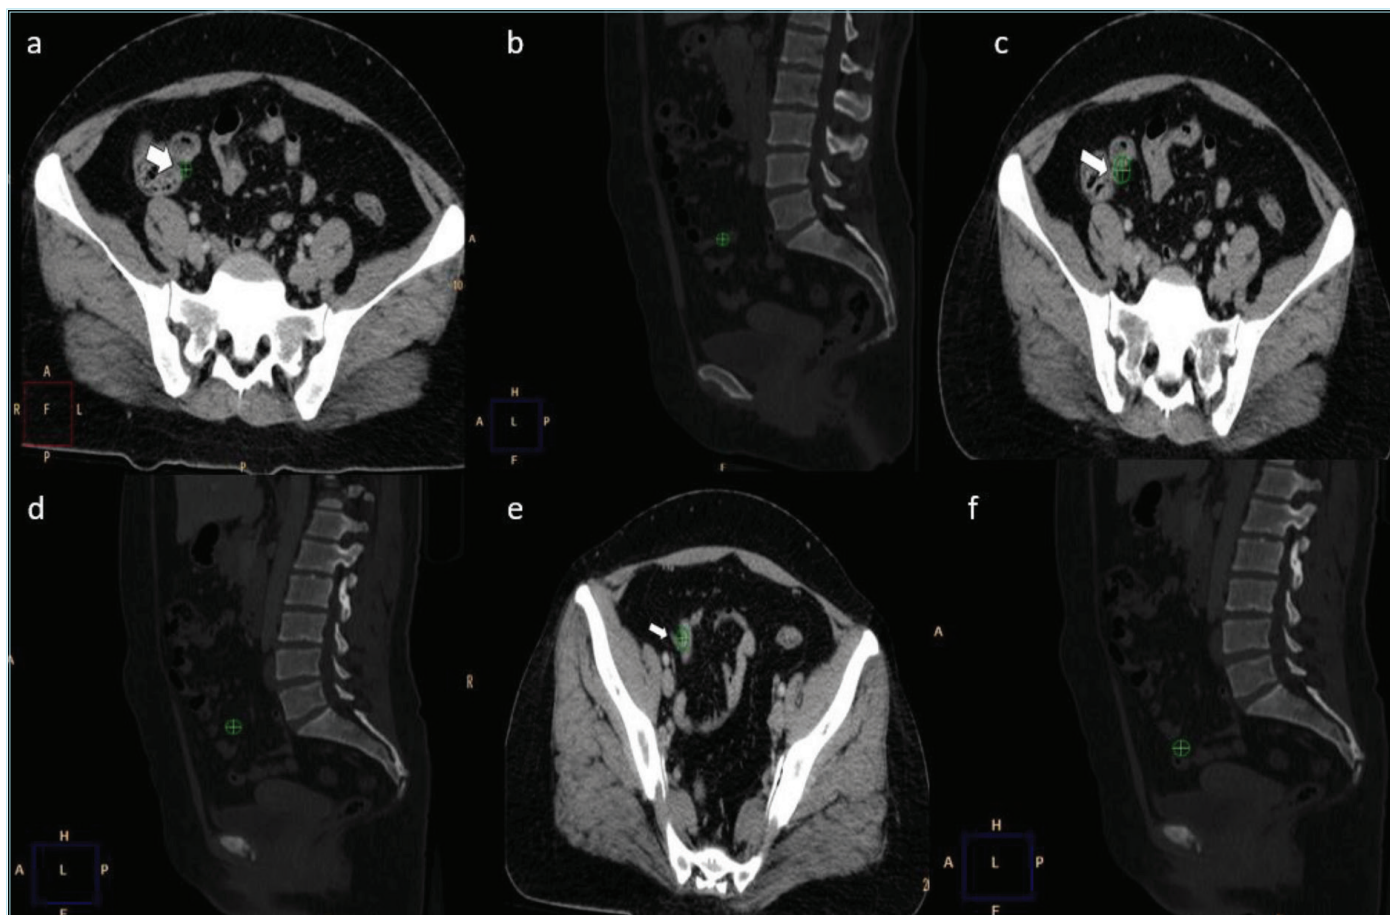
Method for determining the localization of the vermiform appendix using vertebral reference (example from a single patient). (a) The origin at the cecum (Ap0, white arrow) is marked on the axial CT image and corresponds to the L5-S1 intervertebral disc level on the sagittal reconstruction (b, green marker). (c) The highest point of the appendix (ApA, white arrow) is marked on the axial CT image and corresponds to the L5 vertebral body level on the sagittal reconstruction (d, green marker). (e) The lowest point of the appendix (ApB, white arrow) is marked on the axial CT image and corresponds to the S3 vertebral body level on the sagittal reconstruction (f, green marker)
